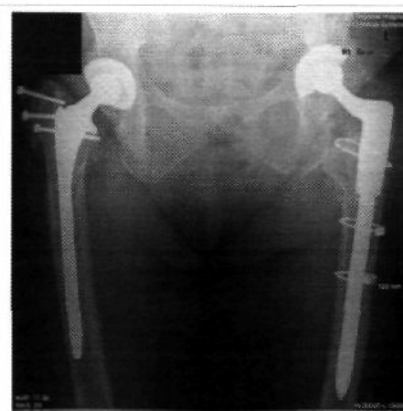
Case 2: Post-operative follow-up radiograph
